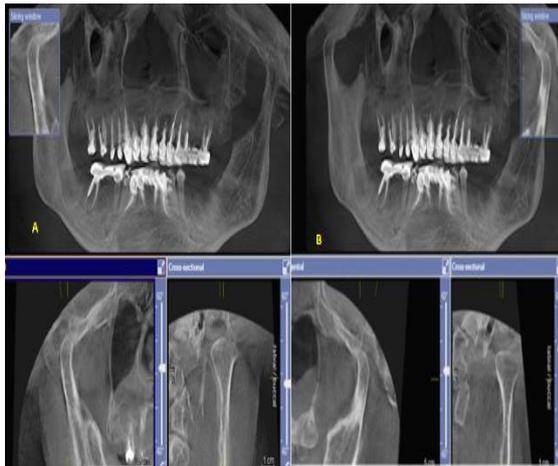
CBCT showing magnified condyles with slight osteophyte present on right side
